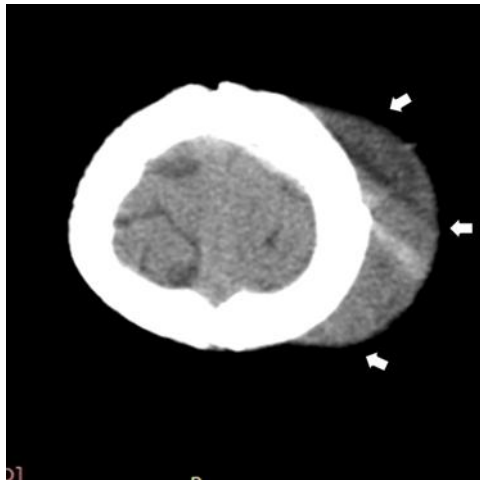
CT of cephalhematoma
